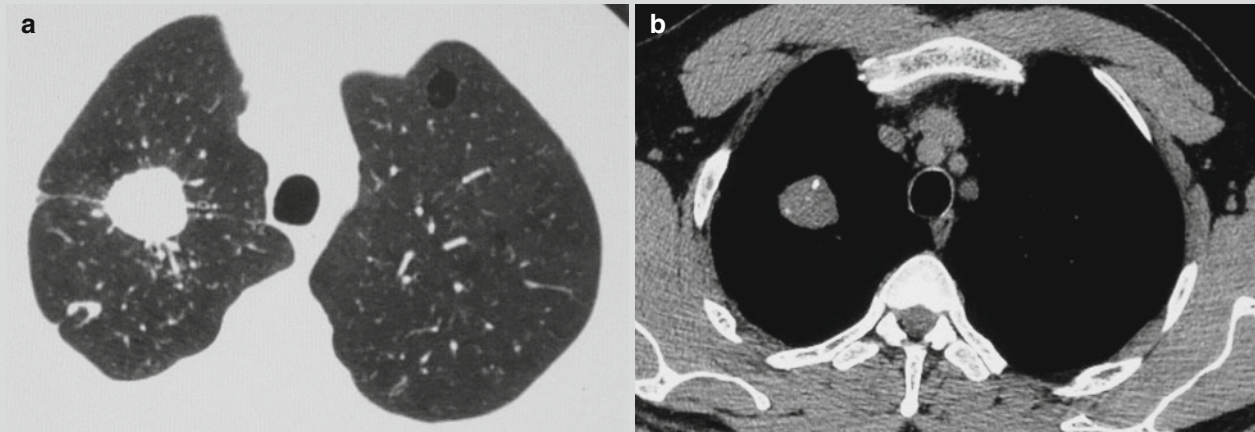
Pulmonary tuberculoma. (a) CT scanning demonstrates round-like nodular shadow at the apical segment of the right upper lung lobe, with a well-defined and smooth boundary, multiple linear
